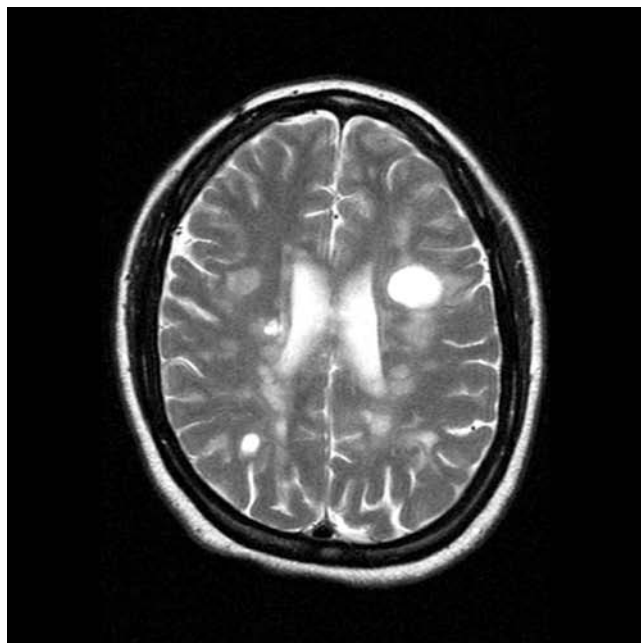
T2-weighted and gadolinium-enhanced T1-weighted magnetic resonance images demonstrating multiple sclerosis plaques in typical periventricular, deep white matter. The juxtacortical location and enhancement are suggestive of active lesions.
